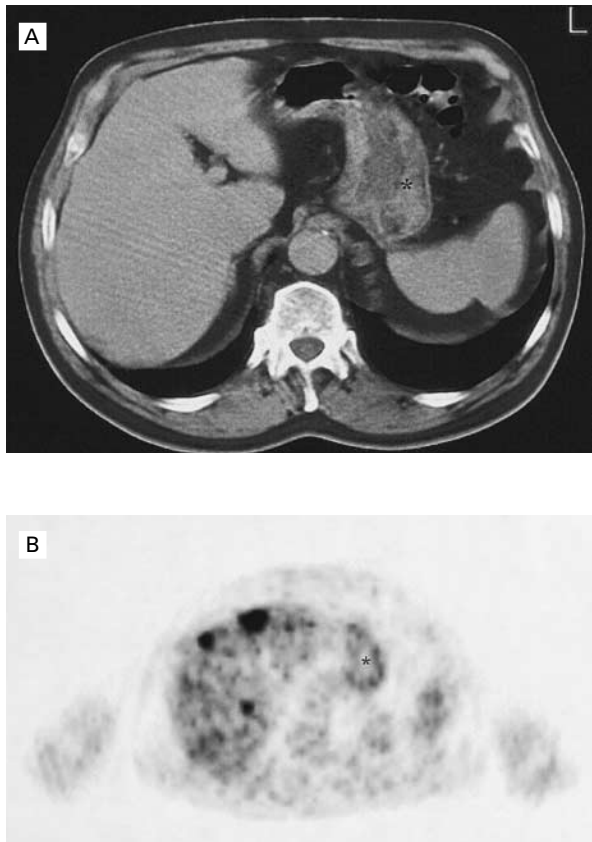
Preoperative Axial CT and PET Findings in a Patient with Non-Small-Cell Lung Cancer.
